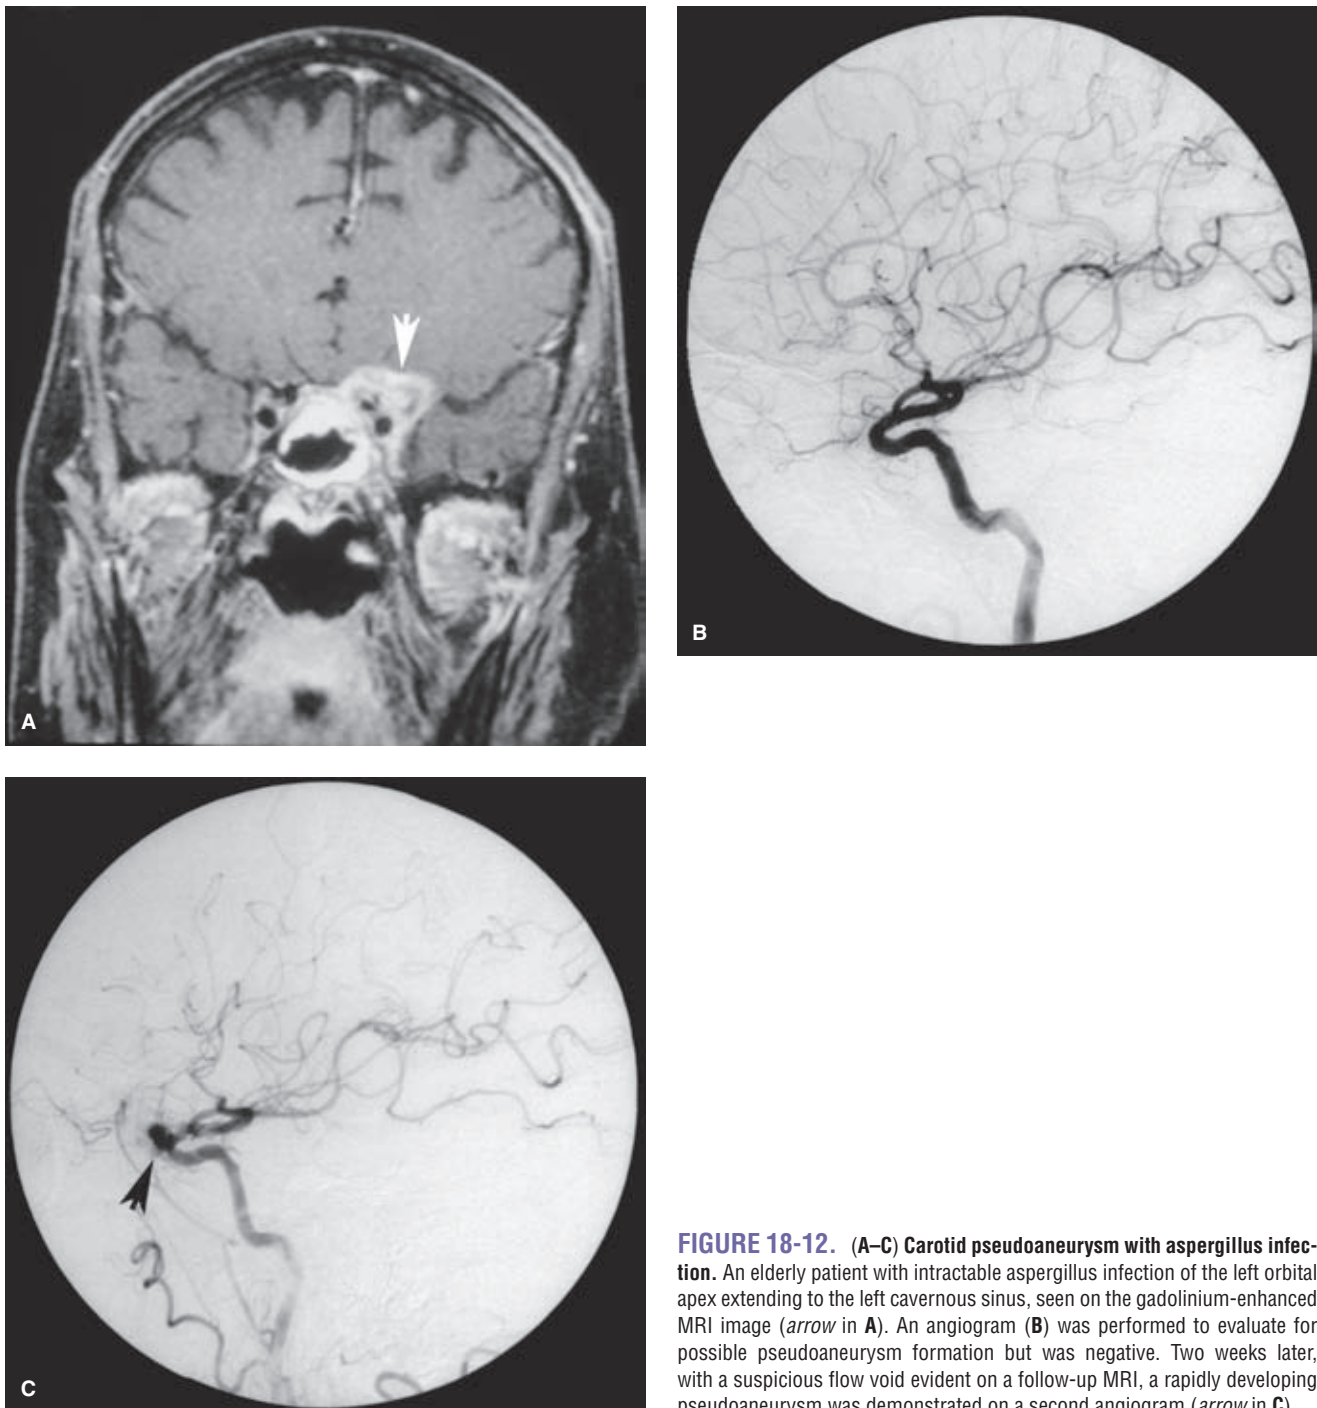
(A–C) Carotid pseudoaneurysm with aspergillus infection. An elderly patient with intractable aspergillus infection of the left orbital apex extending to the left cavernous sinus, seen on the gadolinium-enhanced MRI image (*arrow* in A). An angiogram (B) was performed to evaluate for possible pseudoaneurysm formation but was negative. Two weeks later, with a suspicious flow void evident on a follow-up MRI, a rapidly developing pseudoaneurysm was demonstrated on a second angiogram (*arrow* in C).
